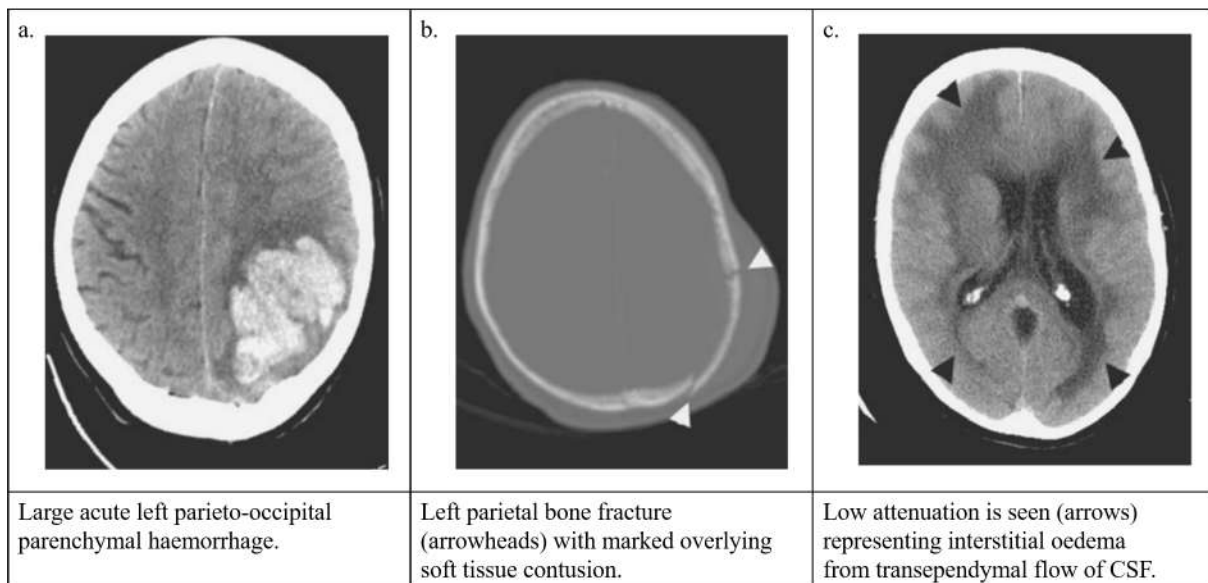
Common TBI injuries on CT. Images from [37]
